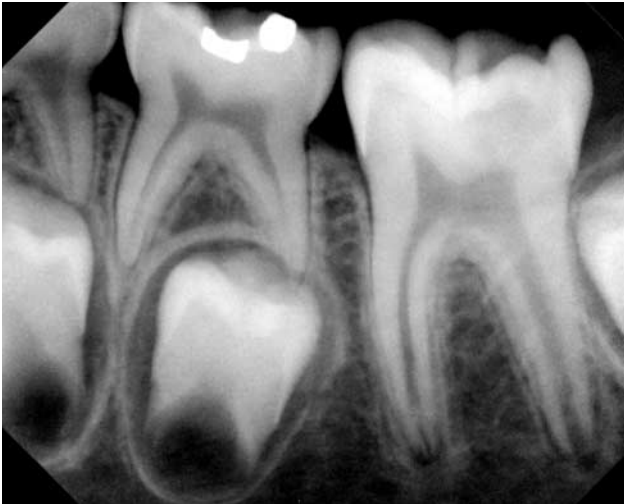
Preoperative radiograph of case no. 16.
